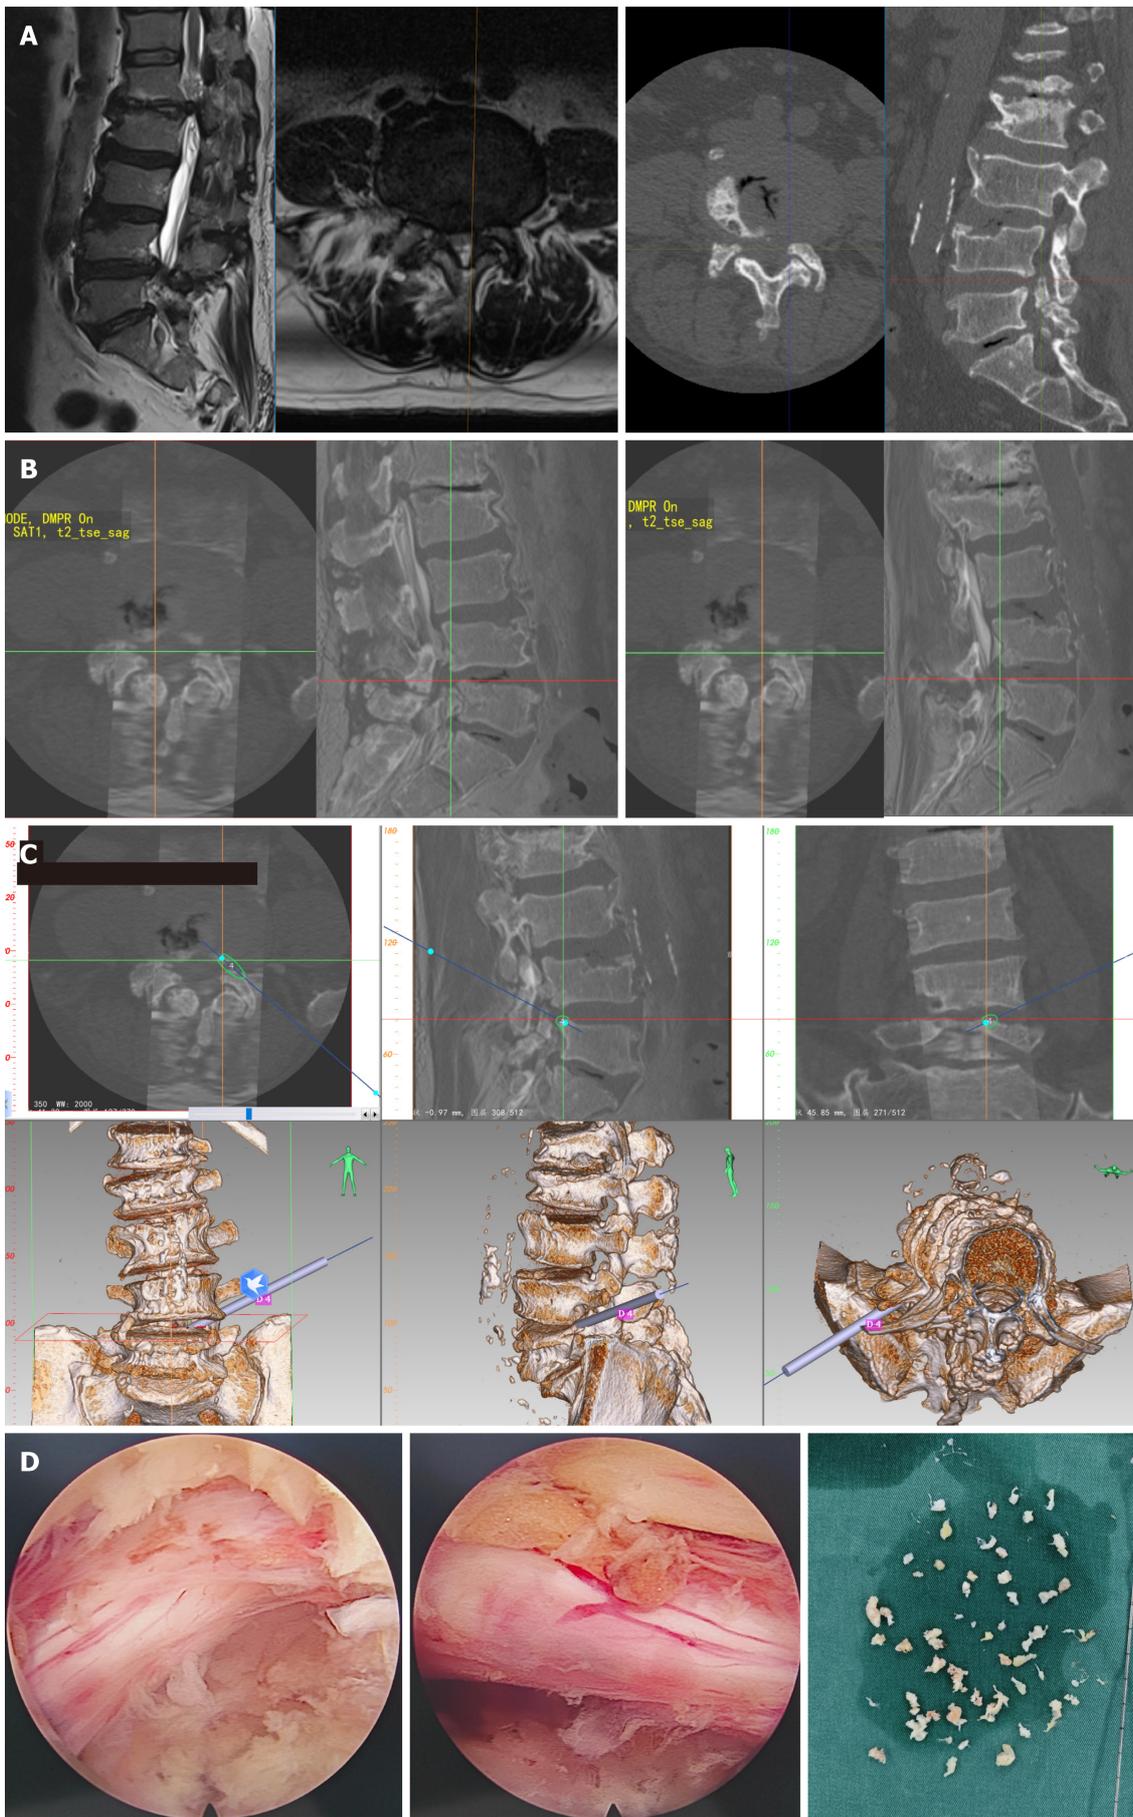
Typical case 2. A: Magnetic resonance imaging and computed tomography images showing lumbar spine stenosis (L4/5); B: Computed tomography
